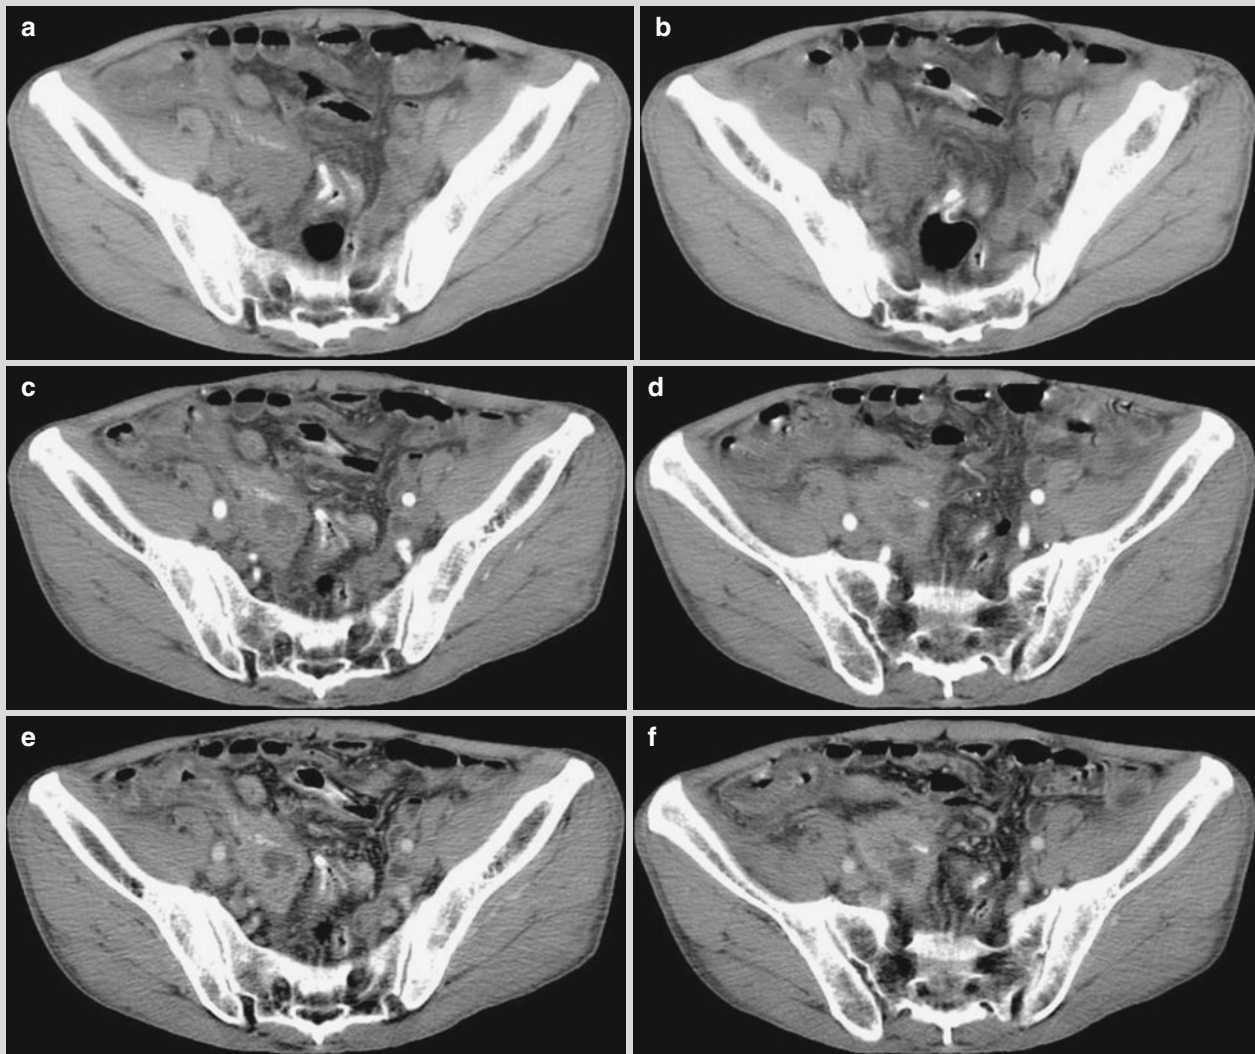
Appendicular schistosomiasis. (a, b) Plain CT scanning demonstrates spindle-shaped lump in the pelvic cavity with soft tissue density, which has coarse boundary and uneven density.
